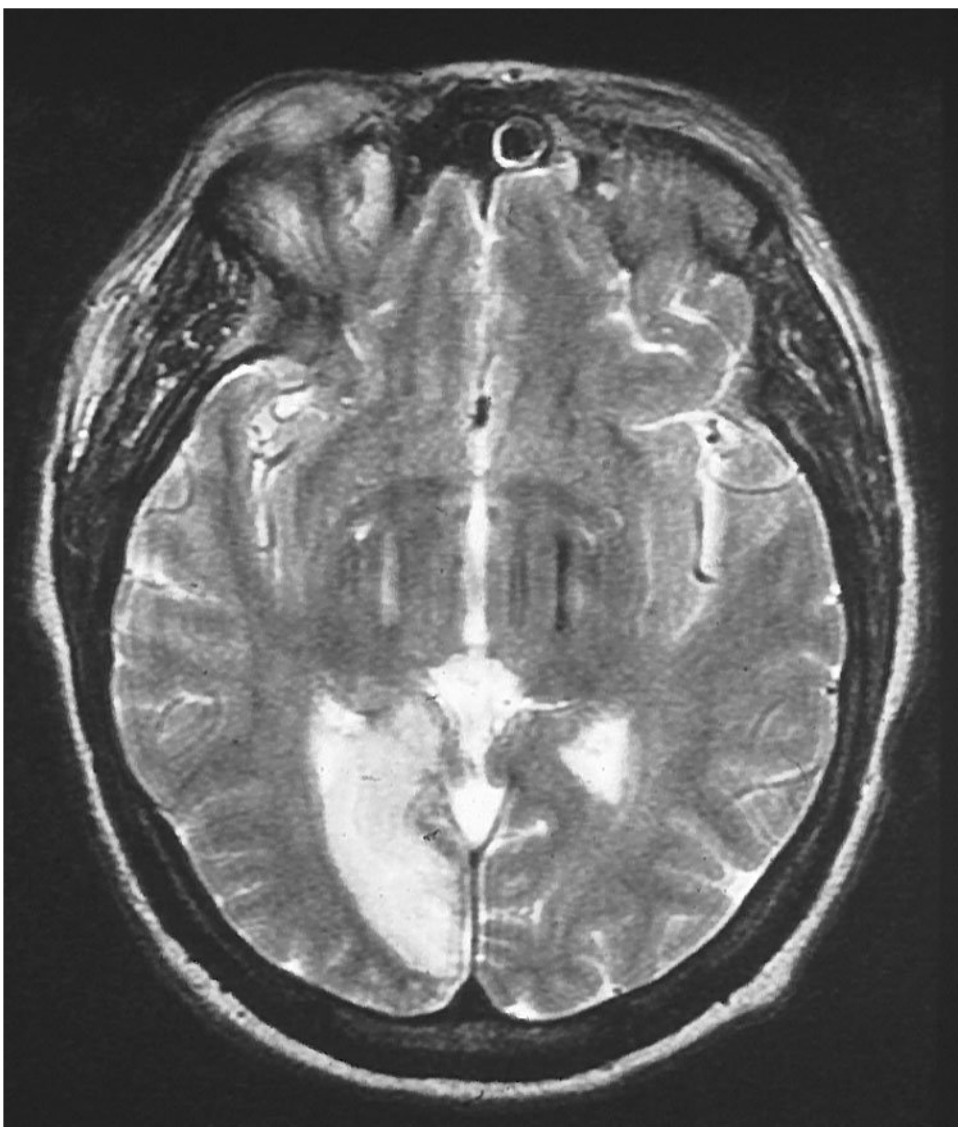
Magnetic resonance imaging study showed a right occipital infarct.
